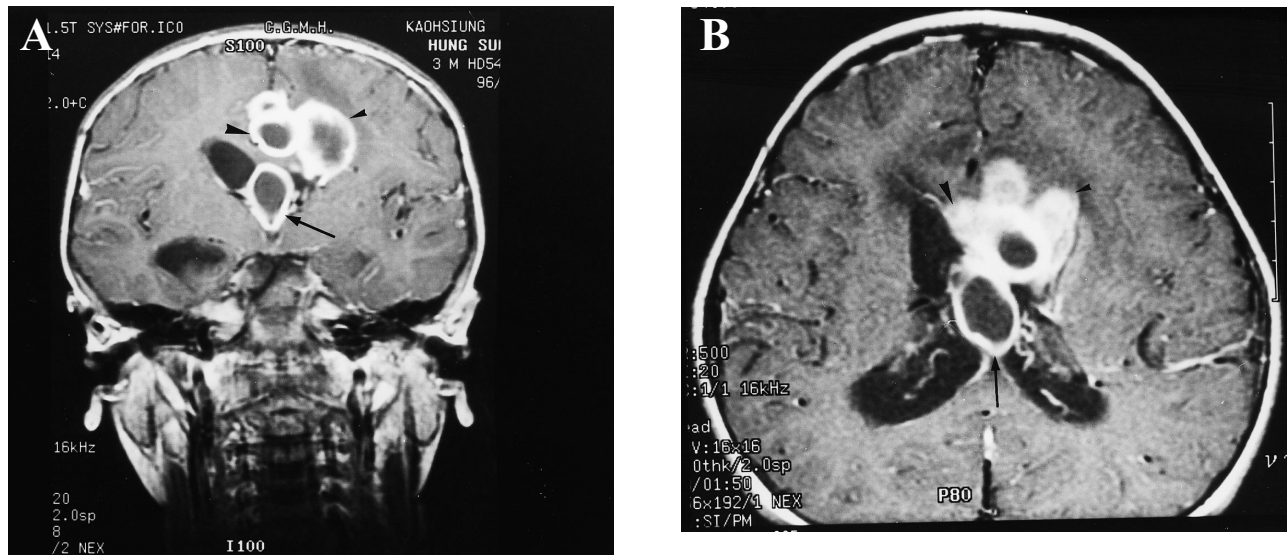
(A) T1W1 coronal and (B) axial views of brain MRI after gadolinium-DTPA contrast administration showing multiloculated ring-enhancing masses at the corpus callosum (large arrowhead), septum pellucidum (arrow), and left frontal region (small arrowhead).
